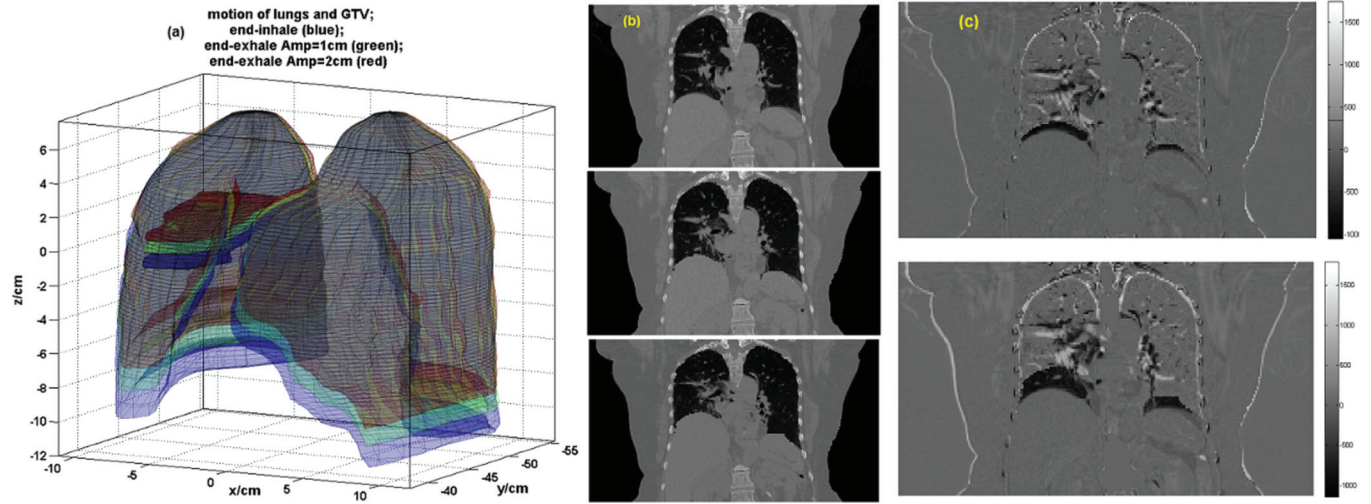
4D model at the end-inhale and the end-exhale phases for breathing amplitudes of 1 cm and 2 cm and the corresponding CT images. (a) lungs and GTV at the end-inhale phase and two end-exhale phases with breathing amplitude of 1 and 2 cm, respectively; (b) CT images at difference breathing phases; top: the end-inhale phase; middle: deformed CT images at the end-exhale phase with breathing amplitude of 1 cm; bottom: deformed CT images at the end-exhale phase with breathing amplitude of 2 cm; (c) difference of the CT images between the end-inhale and the end-exhale phases; upper: 1 cm breathing amplitude; lower: 2 cm breathing amplitudes.
